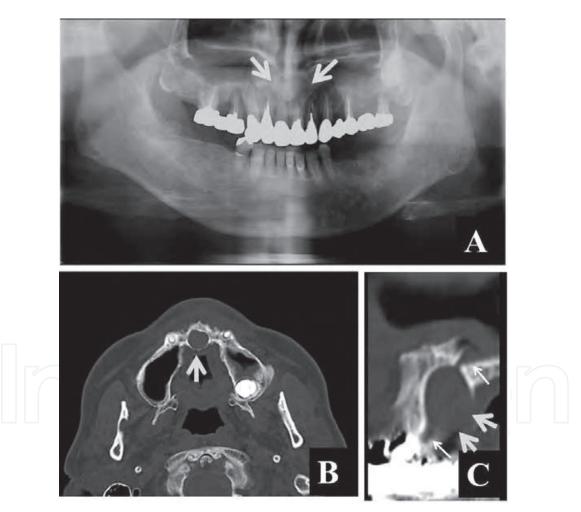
Panoramic radiograph image (A), axial (B) and oblique sagittal (C) CT image of an incisive canal cyst (arrows) and incisive canals (narrow arrows).
